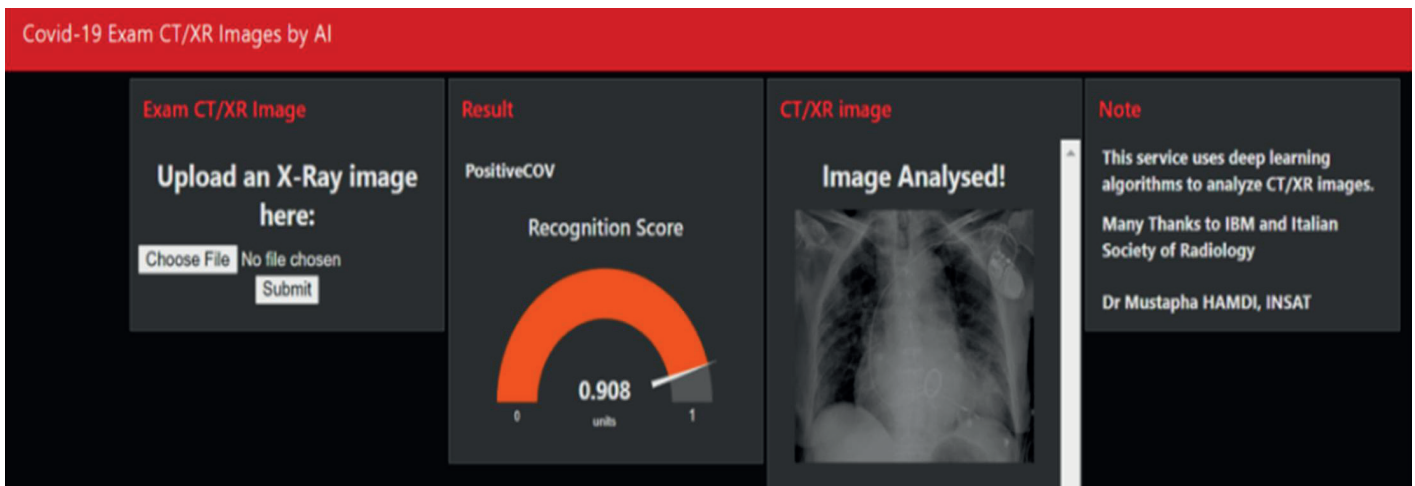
Diagnosis of COVID-19 by AI using radiographs of the lungs performed by radiology technicians.
